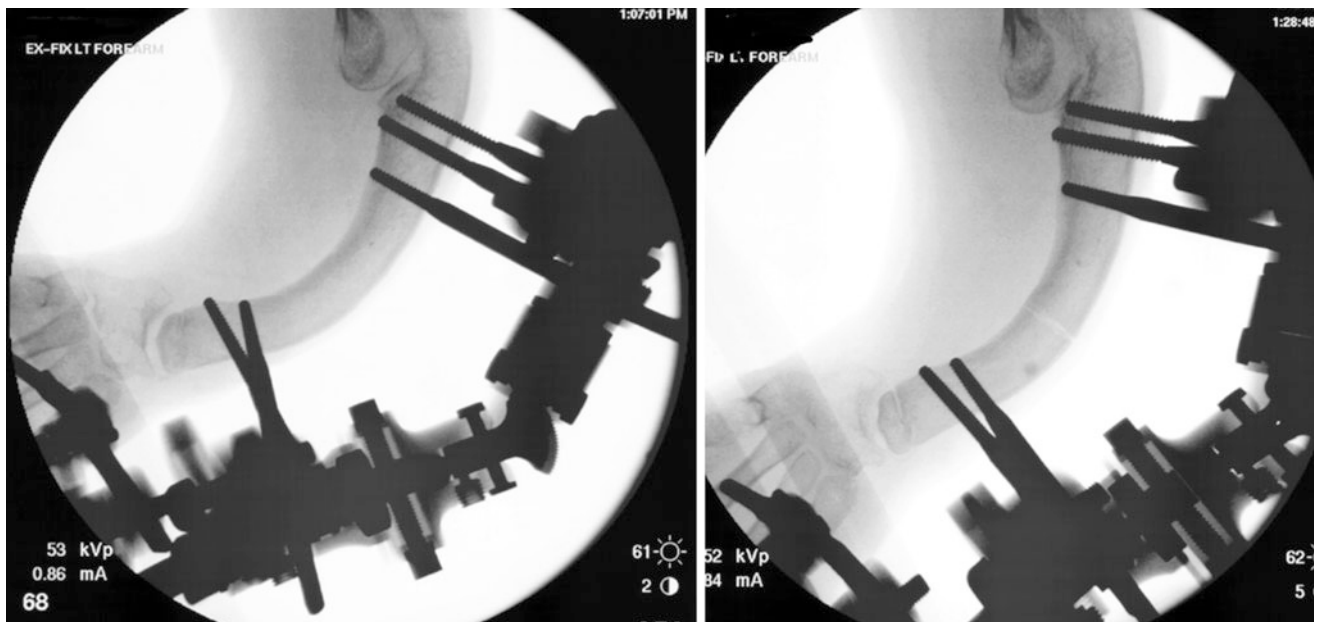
Intraoperative radiographs showing placement of three pins into the proximal ulna, two into the distal ulna, and two into the metacarpals (stabilizing the wrist). Osteotomy is performed through a small incision at the CORA
